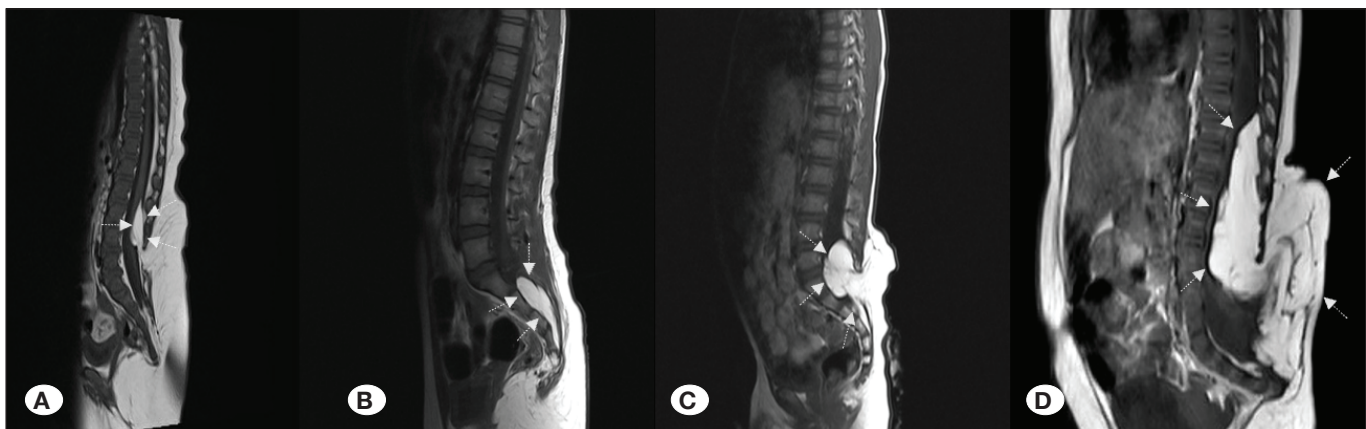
Lumbosacral lipoma classification using a T1-sequence magnetic resonance image. A) Dorsal, B) caudal, C) transitional, and D) chaotic.
